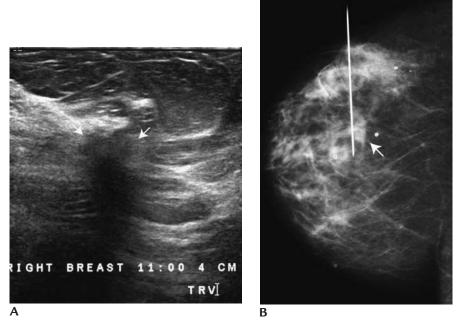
Ultrasound-mammographic correlation. (A) In evaluating a patient with a spiculated mass in the right breast detected mammographically, an area of intermittent shadowing (*arrows*) is imaged in the right breast on ultrasound. If there is any concern regarding the correlation between mammographic and sonographic findings, the needle used for local anestthesia (25G) is placed through the sonographic finding, and a follow up mammographic image is done. (B) Craniocaudal view confirms that what is seen on ultrasound corresponds to the spiculated mass (*arrow*) seen mammographically. The needle is coursing through the anterior edge of the spiculated mass. The patient is returned to the ultrasound room and two cores are done through the mass establishing the diagnosis of an invasive ductal carcinoma.
